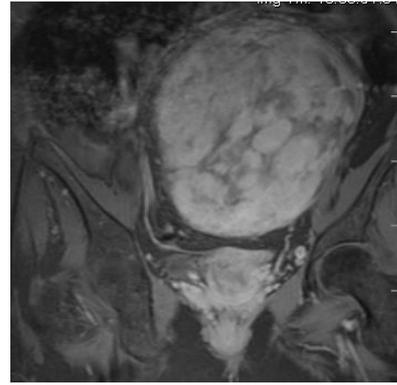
MRI showing areas of degenerations and necrosis.
